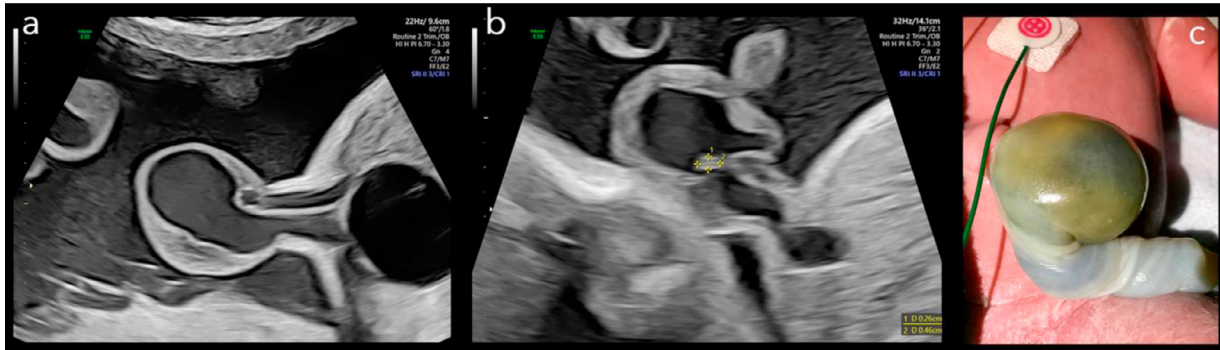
(A) 2D-ultrasound image of the dilated umbilical vein in a 27-year old primigravida at 29 weeks of gestation. (B) presence of the small thrombus. (C) postnatal image of the umbilical cord at day 1 in female neonate.
